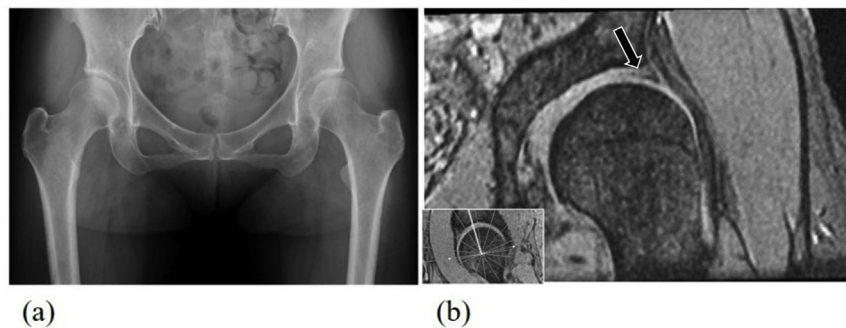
Plain radiograph and magnetic resonance image (MRI) for case 2, showing (a) acetabular dysplasia on the plain radiograph, and (b) the labrum tear (arrow), in an anterolateral position, on MRI.
